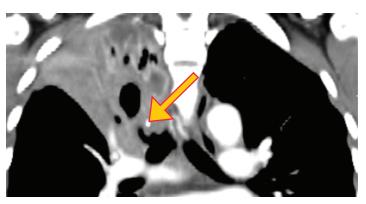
Coronal contrast-enhanced reformatted chest CT image at the level of the central bronchi shows irregular thickening of the right upper lobe bronchus (arrow), as well as right upper atelectasis.
